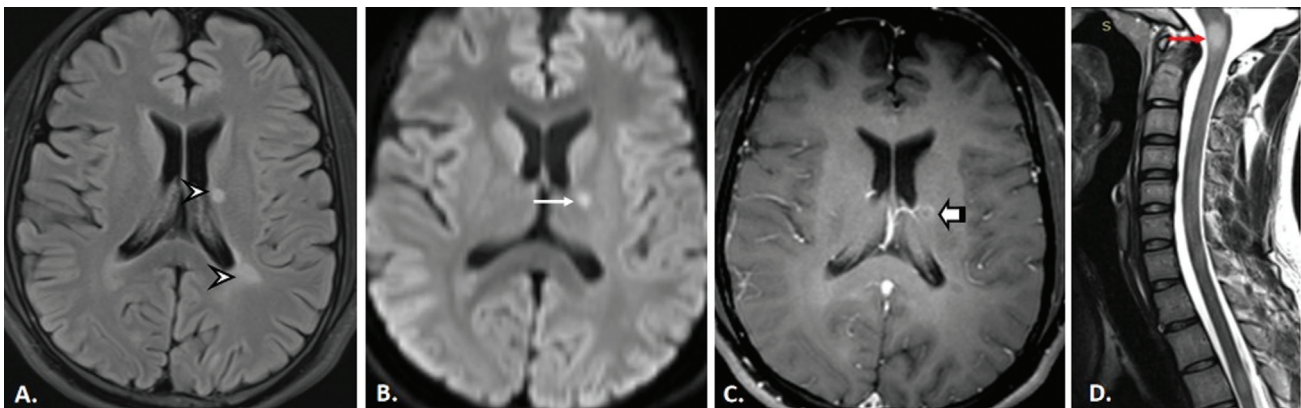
Multiple sclerosis. (A, B) Axial fluid-attenuated inversion recovery image showing multiple small hyperintense lesions in periventricular and subcortical areas (arrowhead). (C) Axial diffusion-weighted imaging showing few of lesions showing diffusion restriction (arrow) suggesting active lesions. However, the lesions showing no diffusion restriction suggest old lesions. (D) Axial contrast-enhanced T1-weighting image showing ring like enhancement in the active lesions (short striped arrow). (E) T2-weighted sagittal image. There were lesions also in medulla and spinal cord, satisfying the criteria of dissemination in space (red arrow).
